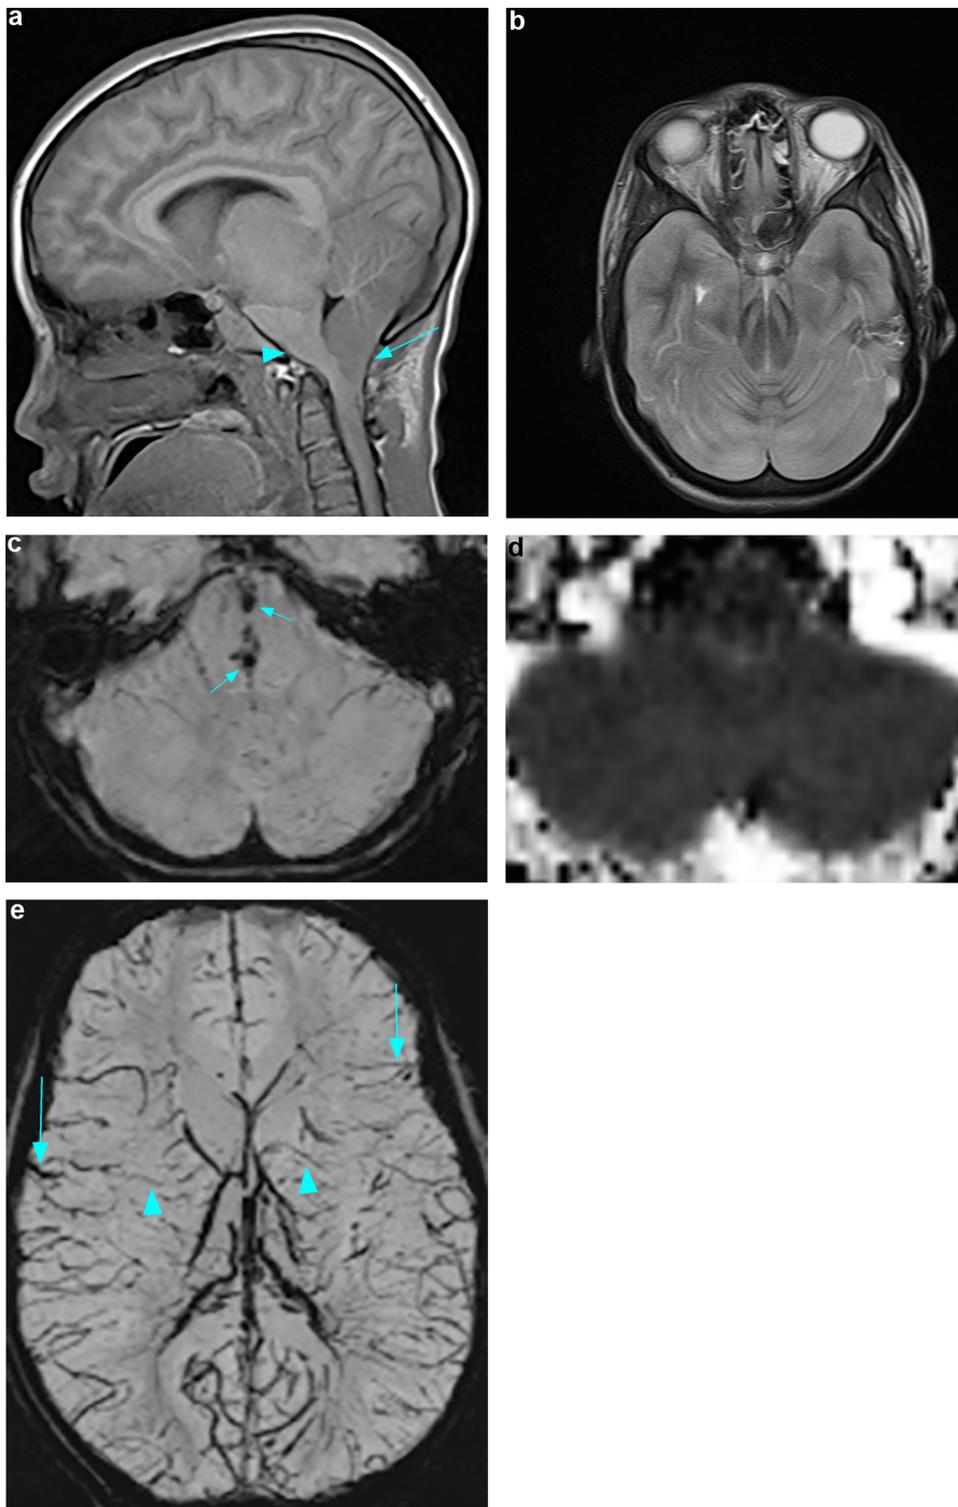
Clinically diagnosed brain death after imaging in an 11-year-old female with anoxic brain injury. (a) Sagittal T1 weighted image demonstrates marked diffuse brain edema with tonsillar herniation (arrow) and brain sagging (arrowhead). (b) Axial T2-weighted images at the level of the pons shows diffuse obliteration of cortical sulci and loss of flow voids within the bilateral ICAs (arrows). (c) Axial susceptibility-weighted image demonstrates Duret hemorrhages in the center of the pons. (d) Axial ADC map demonstrates prominently decreased ADC in the entire brain stem extending to the medulla ($0.25 \times 10^{-5} \text{ mm}^2/\text{sec}$) and cerebellum. (e) Axial susceptibility-weighted image demonstrate transcortical (arrows) and transcerebral (arrowheads) vein signs with prominent medullary veins.
